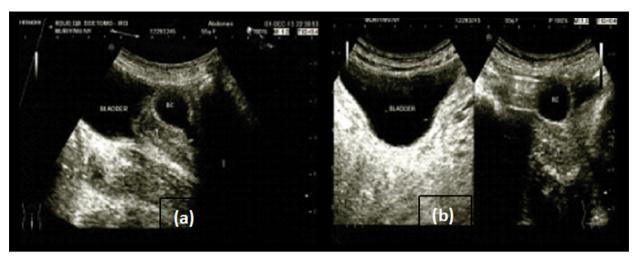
Ultrasound view of the abdomen, (a) sagittal slice, (b) transverse slice.
